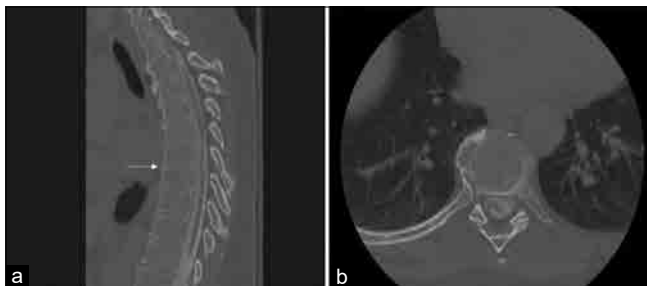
CT myelogram. (a) Sagittal view; arrow pointing to the level of the spinal cord herniation at T7-8, (b) Axial view at the level of the spinal cord herniation at T7-8. CT myelogram.
